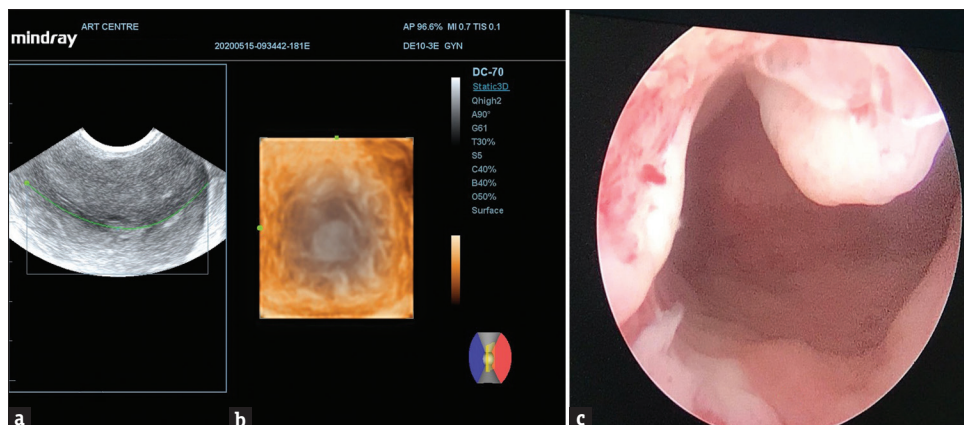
(a) Endometrial polyp as diagnosed by two-dimensional transvaginal sonography; (b) three-dimensional transvaginal sonography and on hysteroscopy; (c) Endometrial polyp
